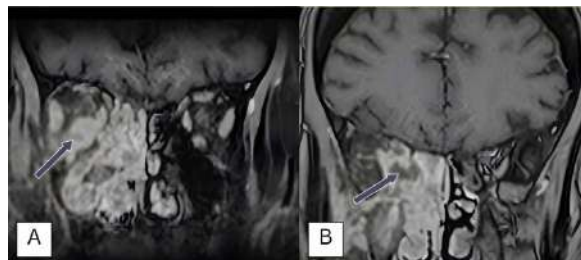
Brain MRI T1 sequence with gadolinium contrast, coronal view, done on Day 22 of admission due to progression of extraocular muscle limitation and ptosis which shows congestion of the extraocular muscles from mass compression (as pointed by the arrow) (A) and extension of mass to right orbital apex. The arrow points to the structure that initially was radiologically thought as abscess (B).
